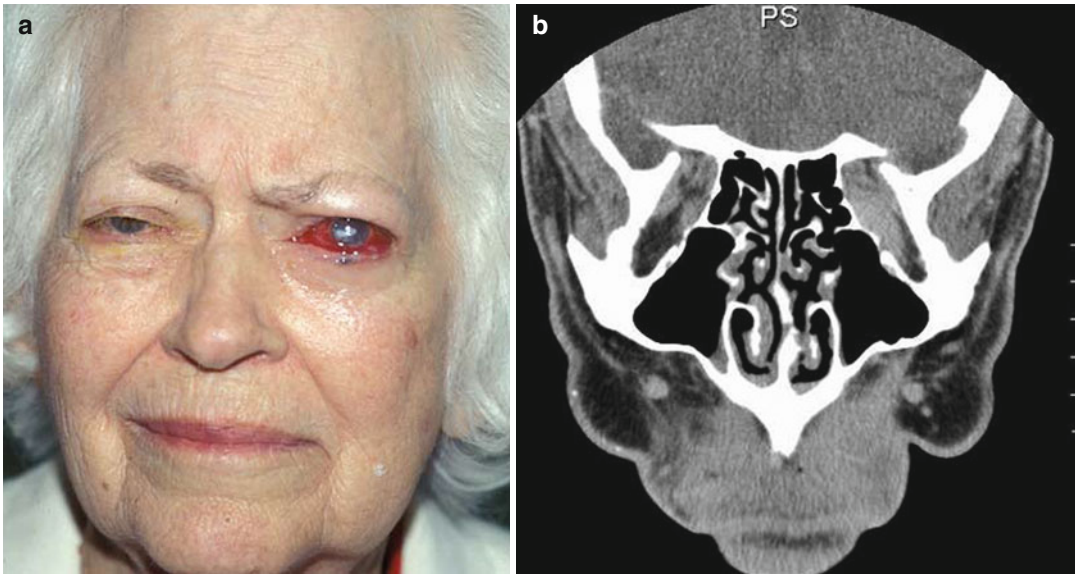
(a) Corneal ulceration causing decreased vision in the left eye of a patient who also had a left optic neuropathy. (b) Same patient from (a). Non-contrast CT scan, coronal view. Note crowding in the left orbital apex but not in the right
